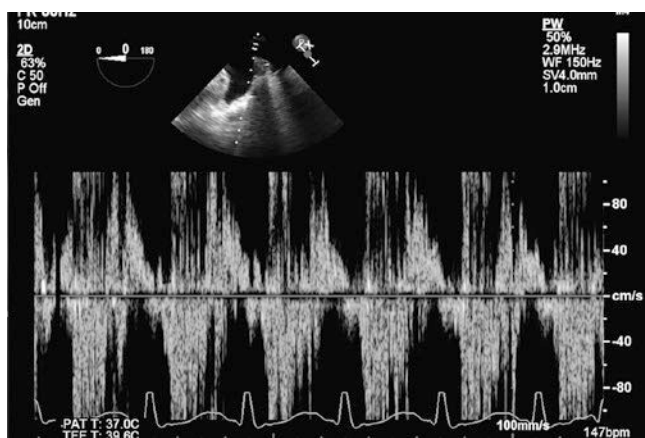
One of the suggestive signs of severe mitral regurgitation is systolic reversal in pulmonary veins, shown here with flow below the baseline when pulse wave Doppler is placed in the pulmonary vein
